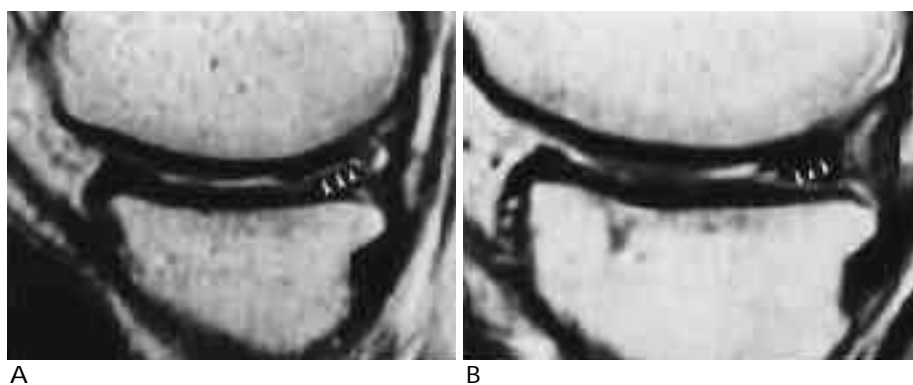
Sagittal proton density-weighted fast SE MR images (TR/TE, 2500msec/14msec) of right knee in a 53 year-old man with horizontal tear of posterior horn of the medial meniscus. Horizontal high signal intensity band of tear (arrowheads) is seen extending to the inferior articular surface on consecutive images (A-B : medial to lateral direction).
